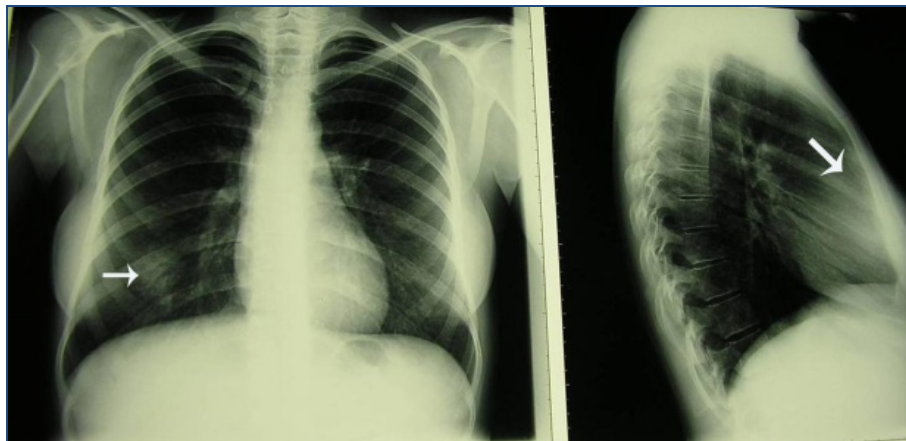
The radiography of thorax: Oval soft tissue change on the basal right lung (arrow, shown at left). Soft tissue change retrosternally (arrow, shown at right).
